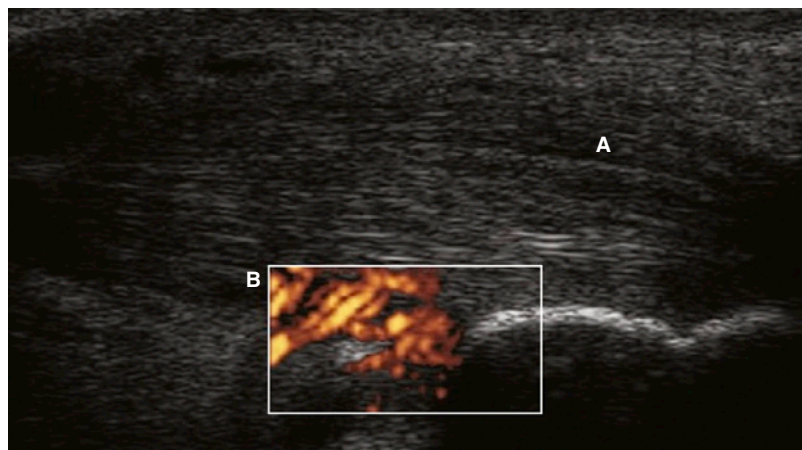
Longitudinal scans reveal increased thickness of the Achilles tendon insertion (A) and inflammatory bursitis on power Doppler (B).
